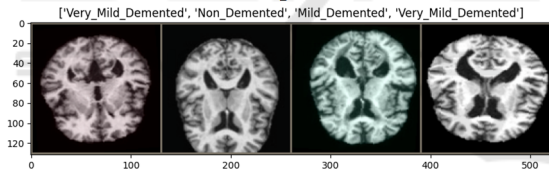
Alzheimer's disease MRI dataset (Photo/Picture credit: Original).
